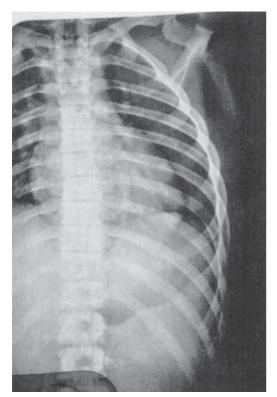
AP chest radiograph. Note that the spinal column actually restricts the normal view of the chest. The AP view is usually used when the patient is not ambulatory and the portable x-ray machine is needed for the bedside.
